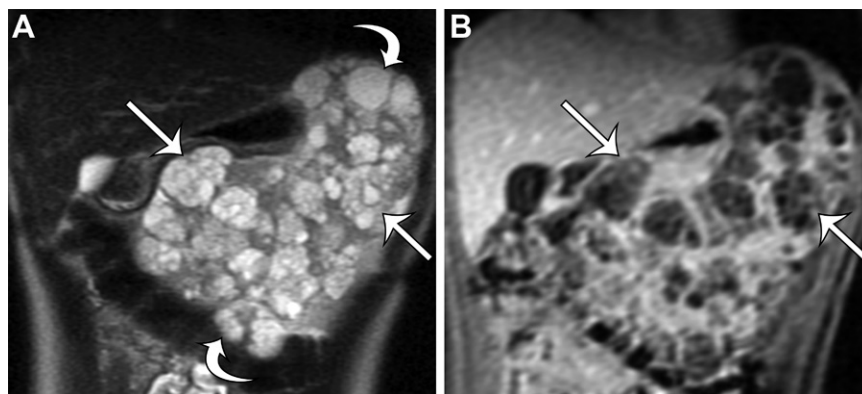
Lymphangioma in a 22-year-old woman with a history of Klippel-Trénaunay-Weber syndrome. (A) Coronal T2-weighted image shows numerous thin-walled unilocular or multilocular hyperintense cystic lesions (curved arrows) of variable sizes throughout the enlarged spleen, with hypointense septa seen within multiloculated lesions (straight arrows). (B) Coronal contrast-enhanced MR image during the equilibrium phase shows progressive enhancement of the septa within the multiloculated lesions (arrows).
